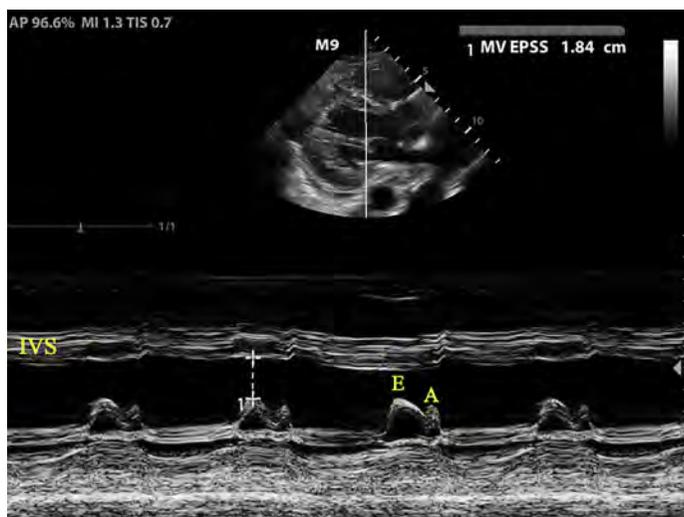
Evaluation of LV systolic function with EPSS. Parasternal long view with M-mode through the anterior leaflet of the MV. In this example, EPSS is 1.8 cm, which suggests severe systolic dysfunction. IVS, intraventricular septum; E, early diastole; A, late diastole.
